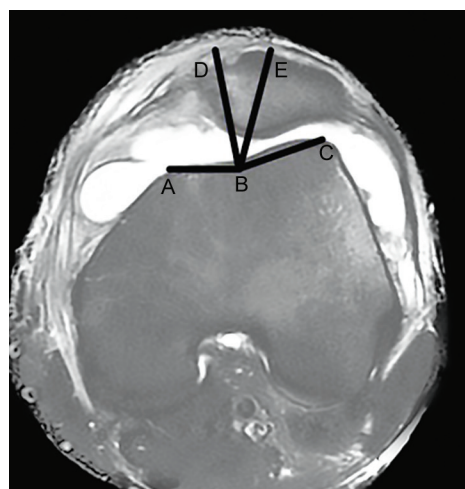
Sulcus angle ($\angle ABC$) and congruence angle ($\angle DBE$) as measured on MRI
